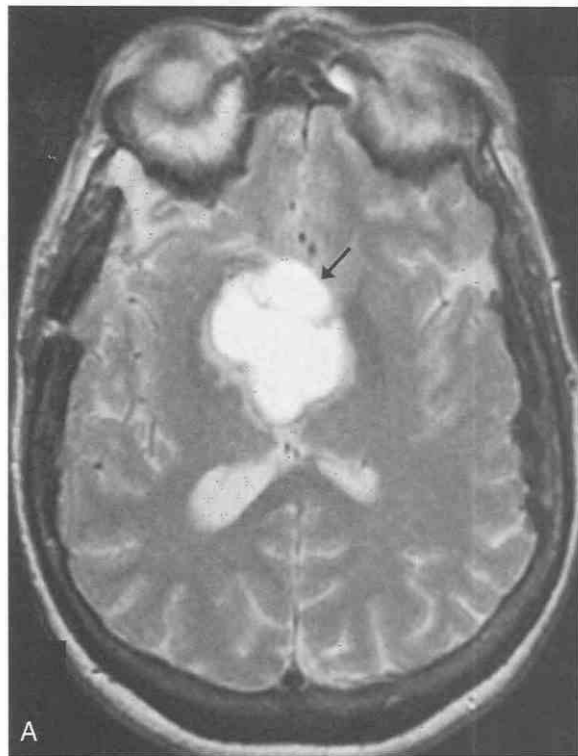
Craniopharyngioma in an adult. A, Axial T2-weighted MR image demonstrates a multilobulated multicystic hyperintense midline tumor (arrow) with irregular margins that has insinuated itself between the basal ganglia of the two cerebral hemispheres. The tumor extends more to the right than to the left of the midline, and the right globus pallidus is compressed and displaced laterally. The cyst contents are more hyperintense than the solid tumor rim in this papillary tumor. Axial (B) and right parasagittal (C) T1-weighted images following intravenous gadolinium demonstrate contrast enhancement of the solid tumor rim (arrow). The cyst contents are hyperintense relative to cerebrospinal fluid, reflecting their high protein content. On the sagittal image, note that this cystic tumor extends into and nearly obliterates the third ventricle with its superior margin projecting into the floor of the right lateral ventricle; posteroinferiorly, the tumor projects into the interpeduncular cistern and displaces the midbrain posteriorly.
